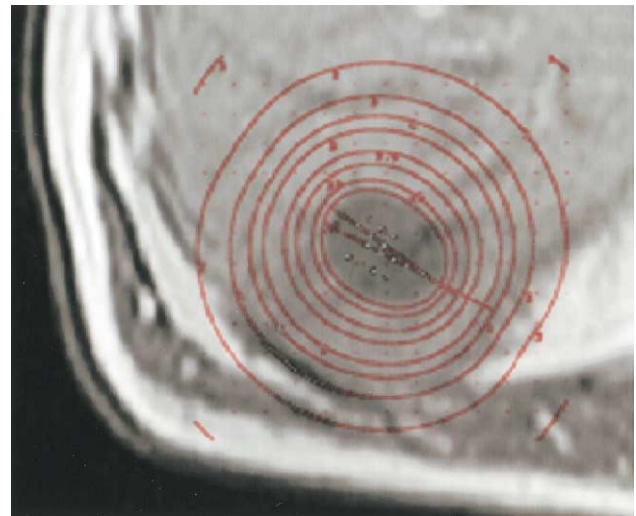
Magnetic resonance imaging acquired 3 days after brachytherapy. Plain T1-w gradient echo. Image fusion with the 3-dimensional dosimetry.
